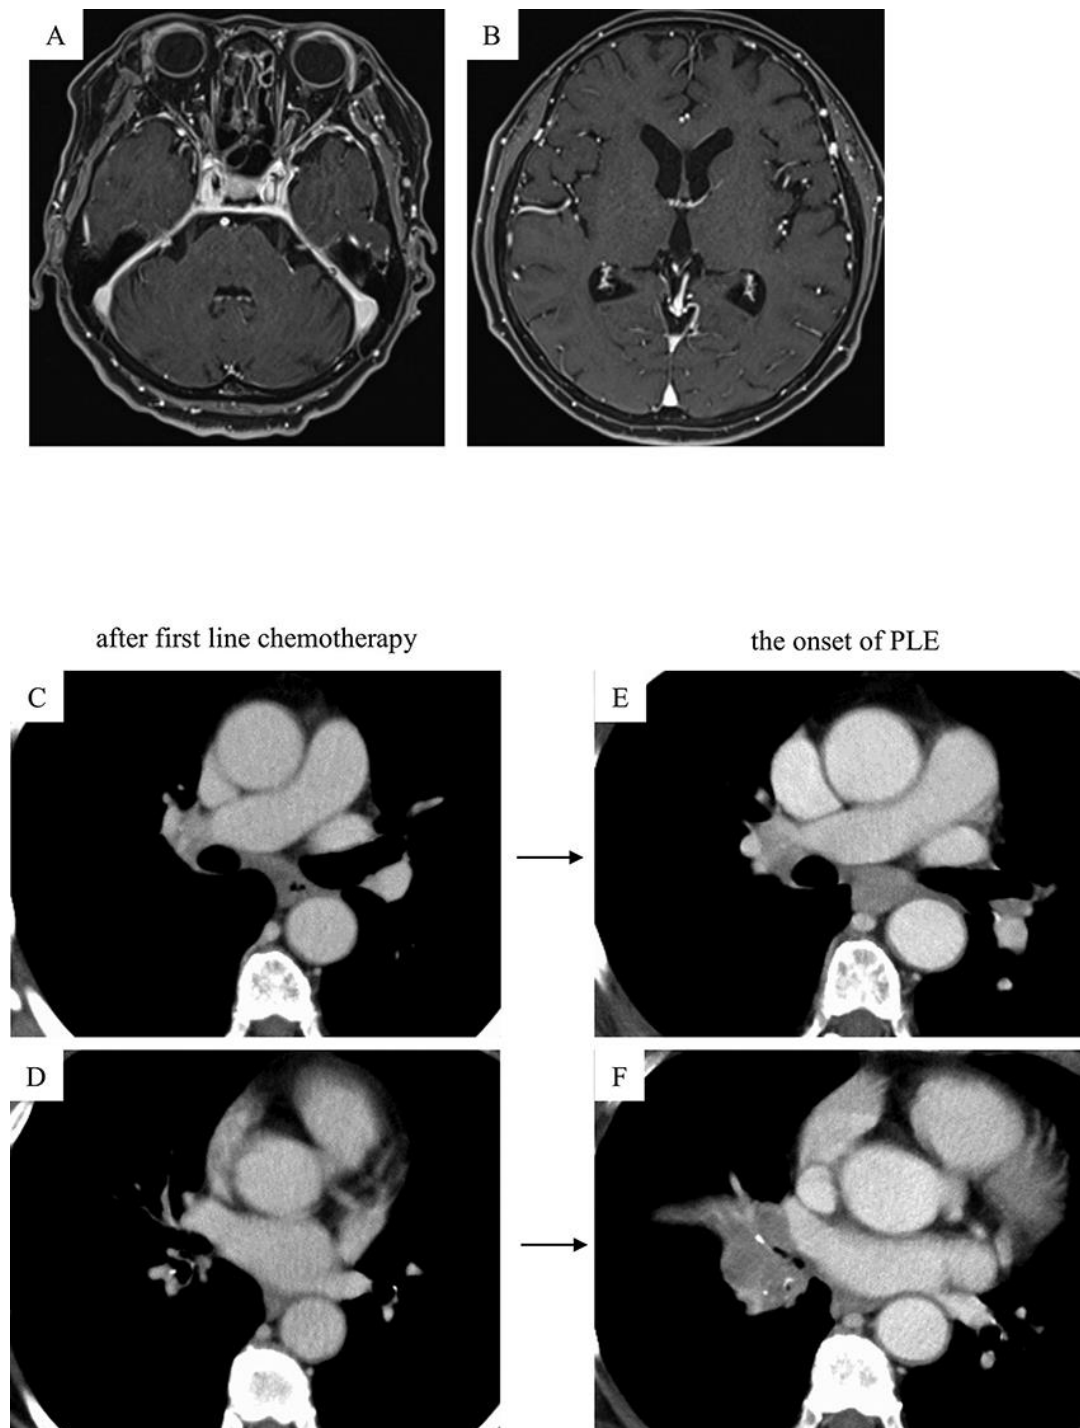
Findings on head MRI and follow-up chest CT. (A, B) Upon the onset of paraneoplastic limbic encephalitis (PLE), head MRI shows no metastatic tumors or stroke. Chest CT shows that compared with the images after first-line chemotherapy (C, D), the images at the onset of PLE (E, F) show increase in the sizes of the right hilar mass and mediastinal lymph node. MRI, magnetic resonance imaging; CT, computed tomography.
